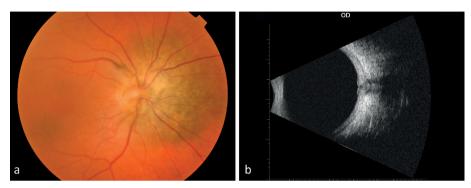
Juxtapapillary naevus, barely elevated, with margin located < 3 mm to the optic disc in the right eye of a 72-year-old man. Figure 6b. High reflectivity on B-scan ultrasonography.
